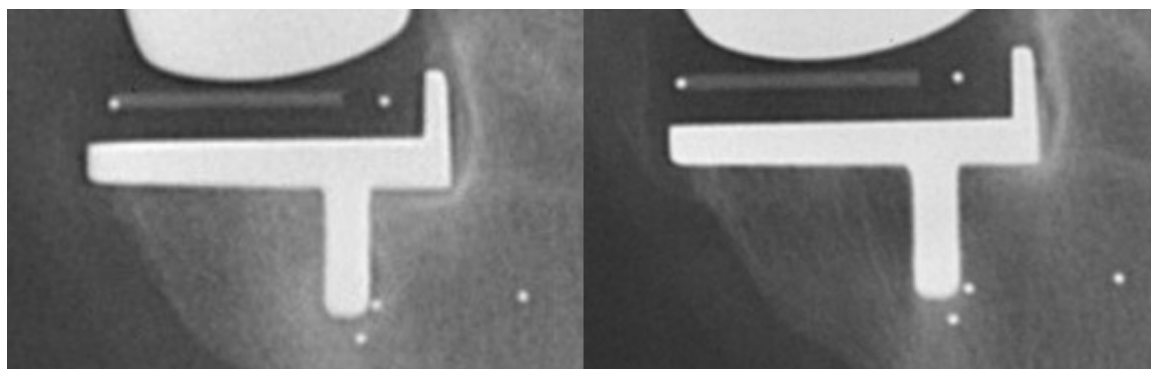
The radiograph on the left, at six months, shows a radiolucency around the keel and in zone 6, with the radiograph on the right, at one year, showing resolution of the peri-keel radiolucency and reduction of the radiolucency in zone 6.
